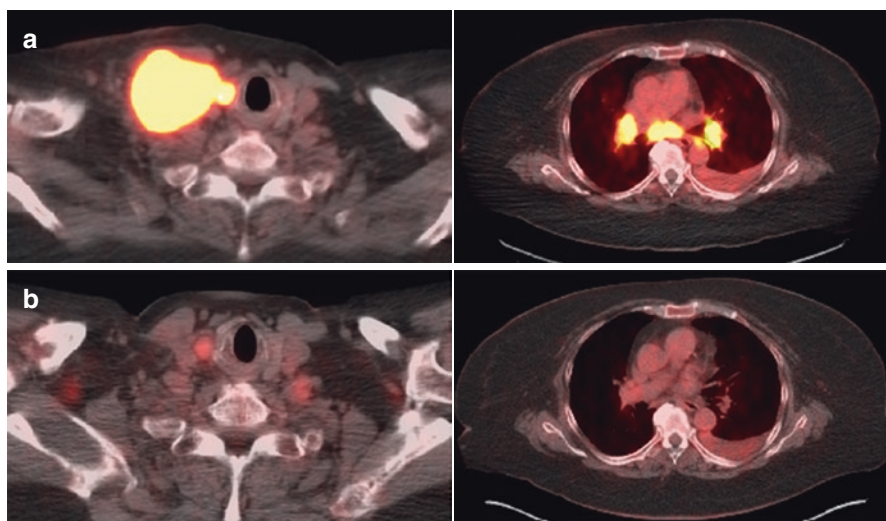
Pre- and post-treatment FDG-PET/CT imaging. (a) Baseline FDG-PET/CT imaging showing a right supraclavicular mass with an SUV of 32, a small right-sided thyroid nodule in the neck (left panel), and multiple mediastinal adenopathy and left pleural effusion (right panel). (b) FDG-PET/CT was performed after treatment with dabrafenib/trametinib for 2 months, showing near resolution of metastatic lymphadenopathy in the neck and lungs. The right thyroid nodule shows significantly less metabolic activity
